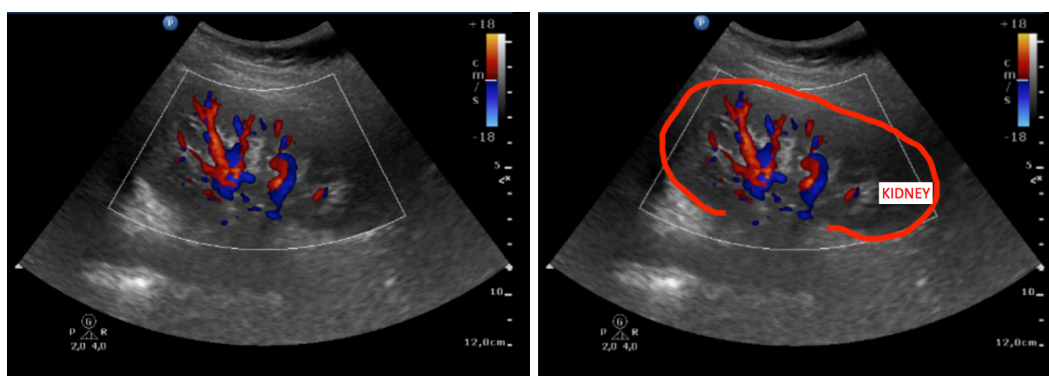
Ultrasonographic image of the left kidney in Doppler mode. It helps to show the position of major blood vessels and the direction of blood flow.
